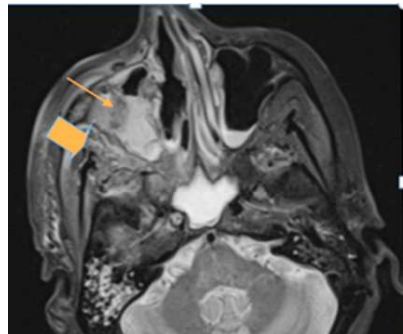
Magnetic Resonance Imaging brain (axial section) shows mucosal thickening with air fluid levels noted in bilateral maxillary sinus (Arrow) (right more than left). Mucosal thickening in sphenoid sinus (Bold Arrow). Edema noted in right premaxillary and retro maxillary region
